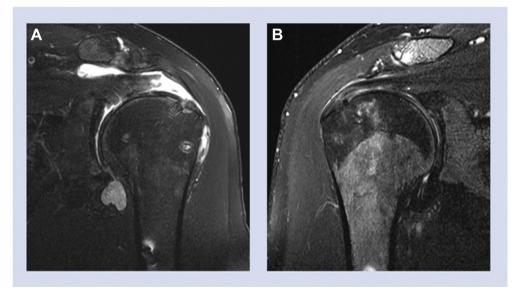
These are two T-2 weighted, coronal magnetic resonance imaging (MRI) snapshots of two of our surgical rotator cuff repair patients 6 months after surgery. (A) This image shows evidence of a fluid-filled gap, and thus, this patient's repair was considered failed. (B) This image shows no evidence of a fluid-filled gap, and this patient's repair was considered healed.
